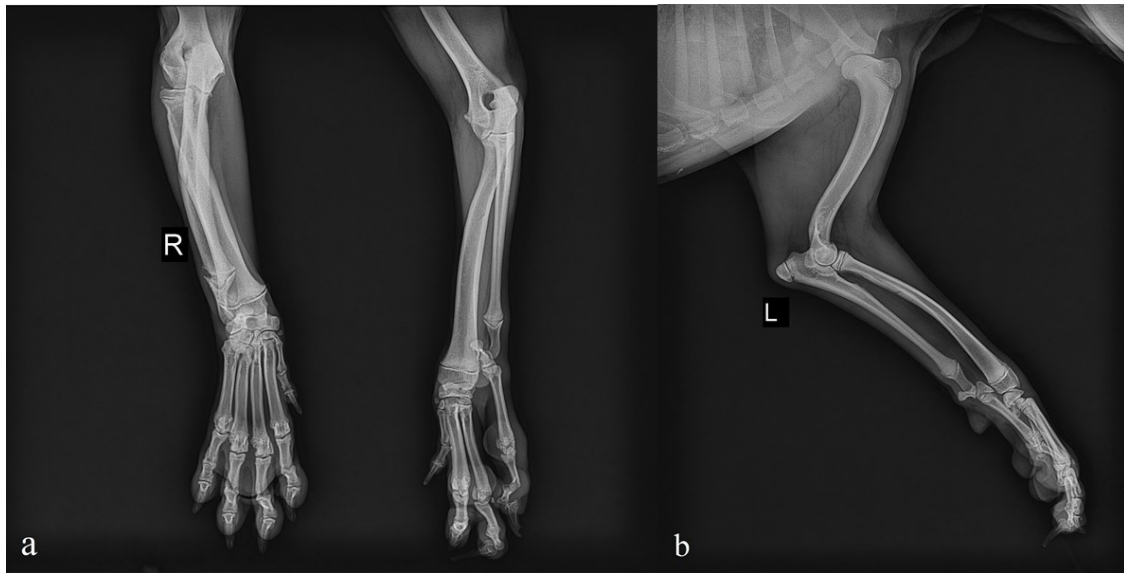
Dorsopalmar (a) and M / L (b) radiographic images of the affected limb.
